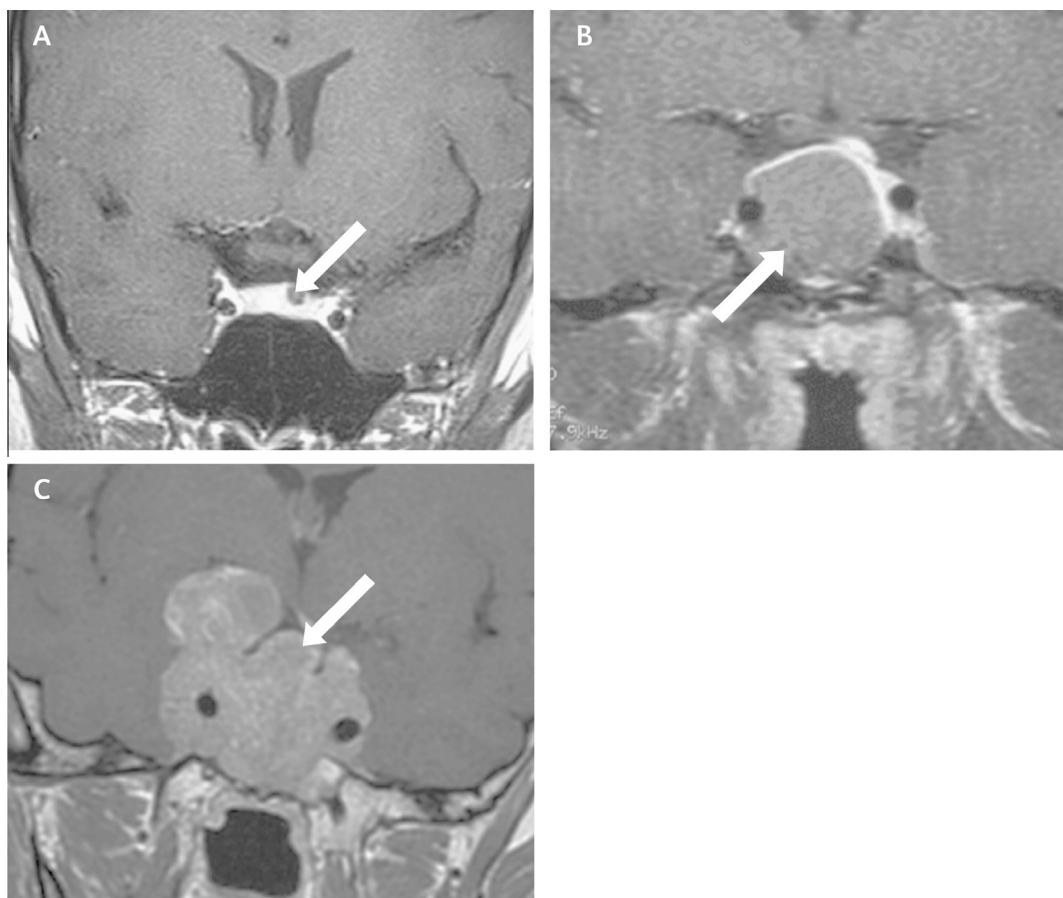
T1-weighted post-contrast MRI scans of (A) pituitary microprolactinoma to the left of midline; (B) non-functional pituitary macroadenoma associated with stalk effect (the pituitary stalk is deviated to the left side with compression and displacement of normal pituitary gland superiorly and to the left); (C) coronal view of a giant macroprolactinoma with extrasellar extension.
